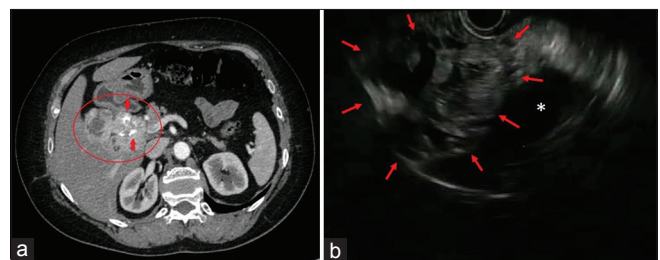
Contrast-enhanced computed tomography scan showing an irregular solid-cystic lesion with irregular margins and inhomogeneous contrast enhancement (circled) in segment V of the liver. Tiny calcifications are visible within the lesion (arrows) (a). B-mode EUS view showing irregular solid cystic lesion adjacent to the gallbladder (*) (b)
